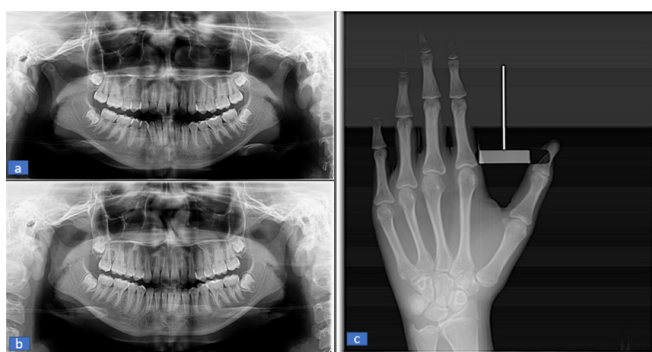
(a) Pre-treatment orthopantomography (b) After treatment orthopantomography (c) Radiography Handwrist.
